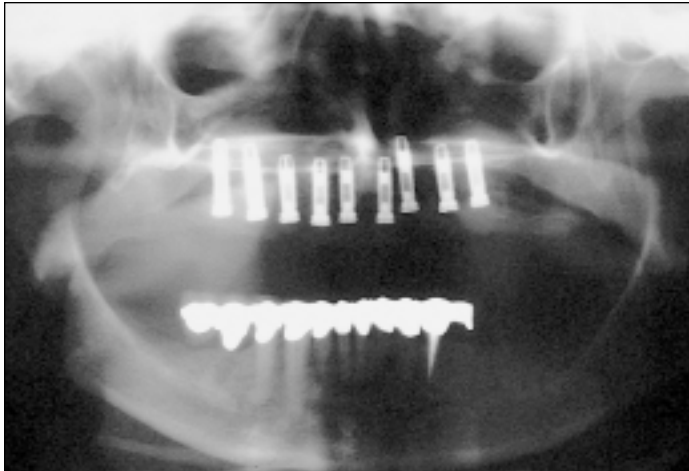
(Right) Radiographic view of the implants.
